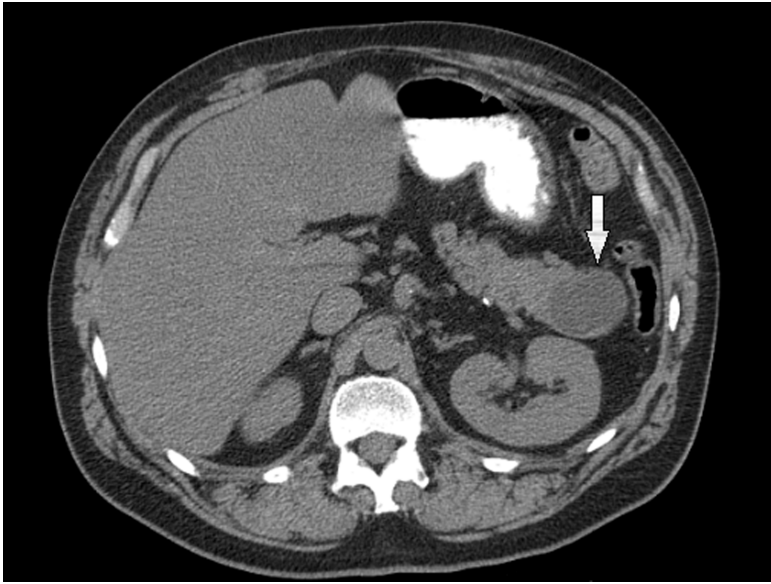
Abdominal CT scan showing a cystic mass in the tail of the pancreas (arrow).
